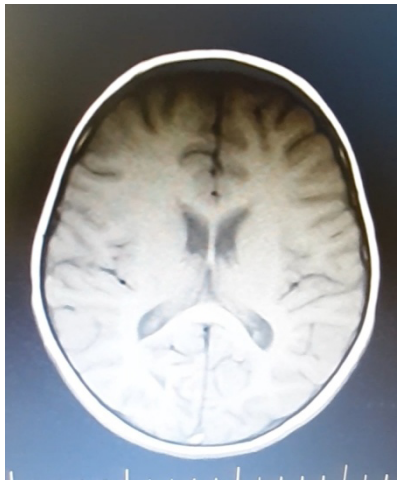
Brain MRI, showing diffuse brain edema
